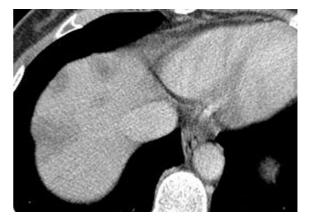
Epithelioid haemangioendothelioma. Transverse contrast-enhanced CT image during the hepatic venous demonstrates multiple peripheral liver lesions showing characteristic target-type enhancement pattern (the so-called, bull's eye appearance), with central hypoattenuating area surrounded by a peripheral thick enhancing ring and outer hypoattenuating halo
